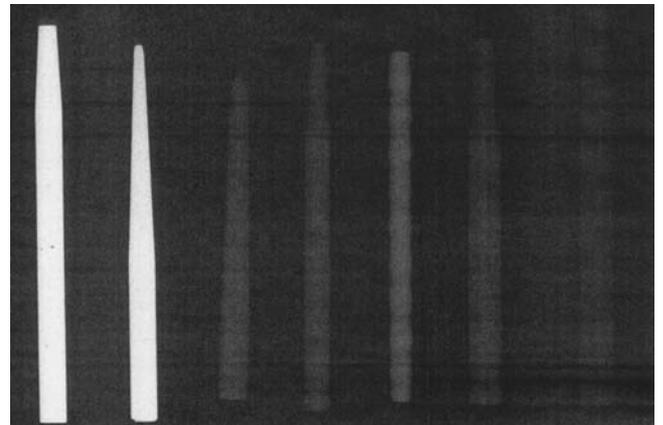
Radiographic images of the posts in Fig. 11.
